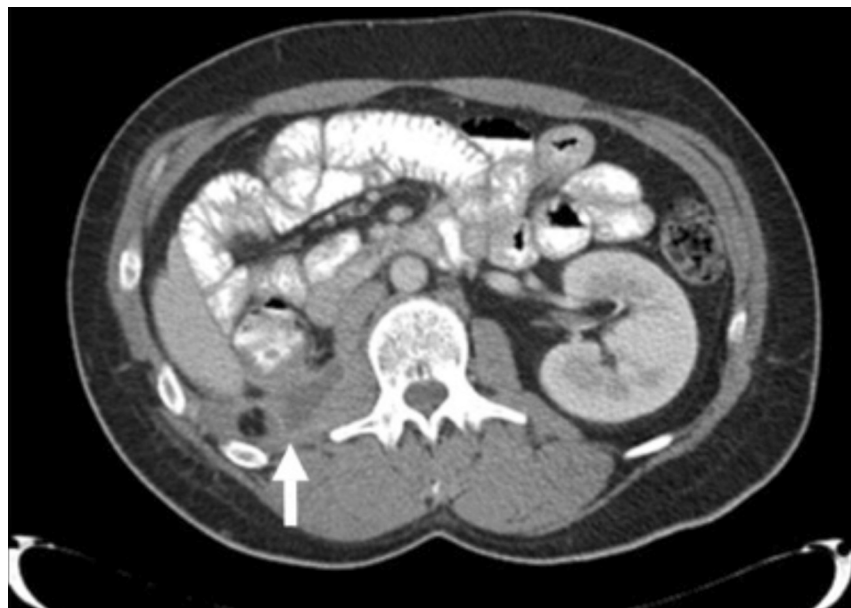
Abdominal CT axial slice showing an irregular collection of fluid in the right retroperitoneum, with characteristic ring enhancement (arrow).
